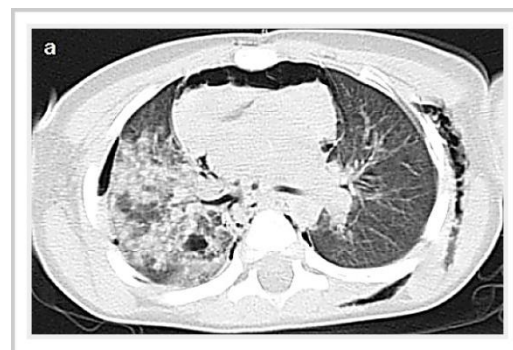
Pneumomediastinum and minimal extra pleural air collections, extensive patchy areas of air space consolidations consistent with contusion and a bleb as a result of laceration in the right upper lobe are seen on axial chest CT (lung window).
